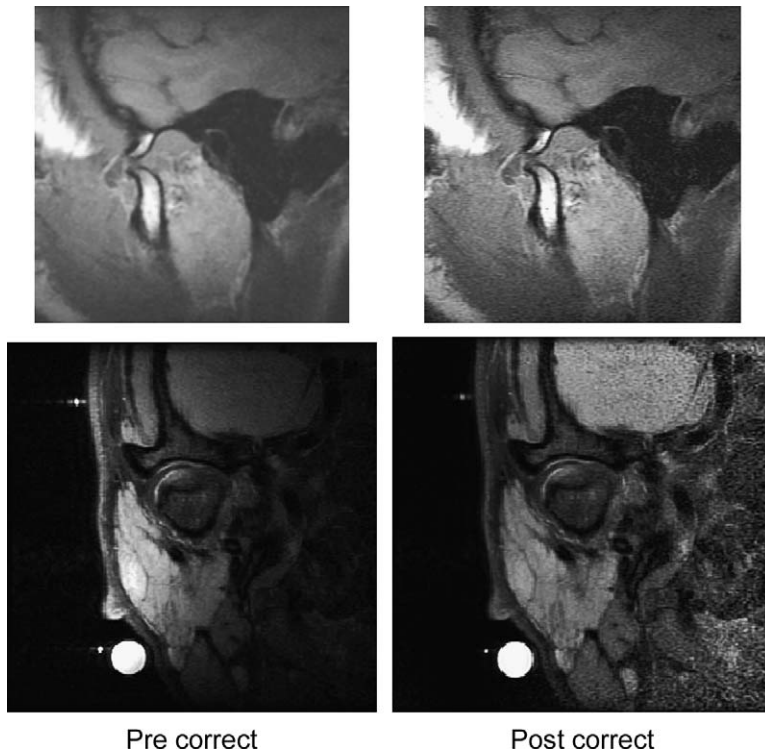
The appearance of pre- and post-corrected MR images in the sagittal and coronal planes.
